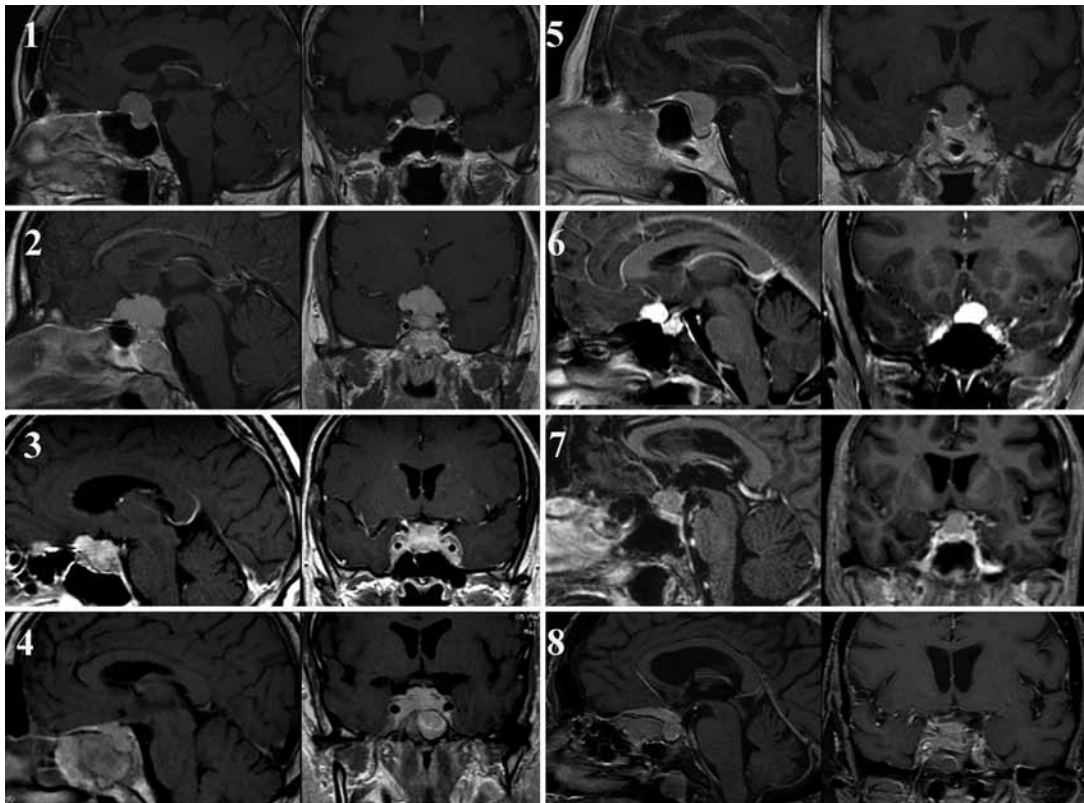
Preoperative sagittal (left) and coronal (right) contrast-enhanced T1-weighted MR images obtained in the first 8 cases (as numbered) in the senior authors' series of 13, demonstrating typical lesions treated with TNE resection. In general these lesions are midline, do not extend outside the carotid arteries, and are relatively small.
